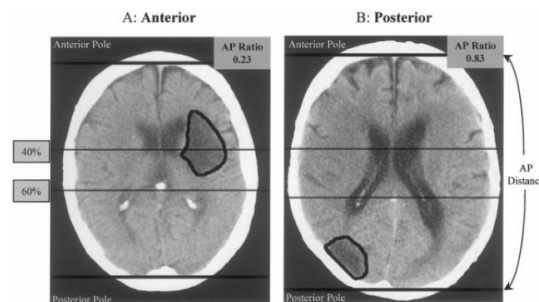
Classification of lesions with CT Analysis(A)
